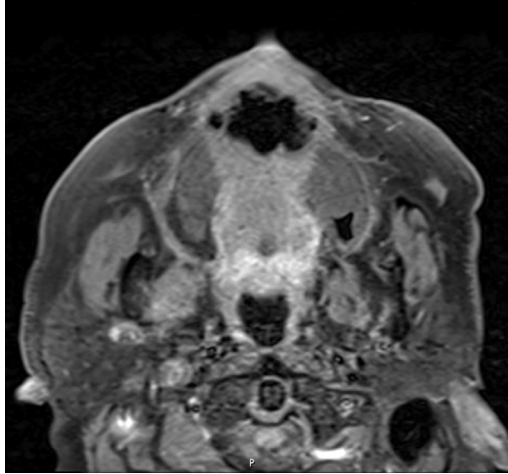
Same patient as in Fig. 2. T2 fat-suppressed MRI showing oronasal fistula secondary to destructive lesion of the hard palate.
